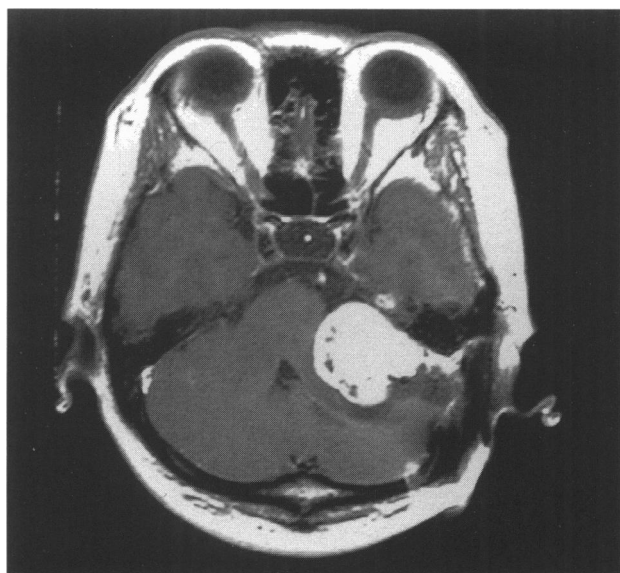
Preoperative MRI in Case 1, revealing a large mass lesion in the cerebellopontine angle.
